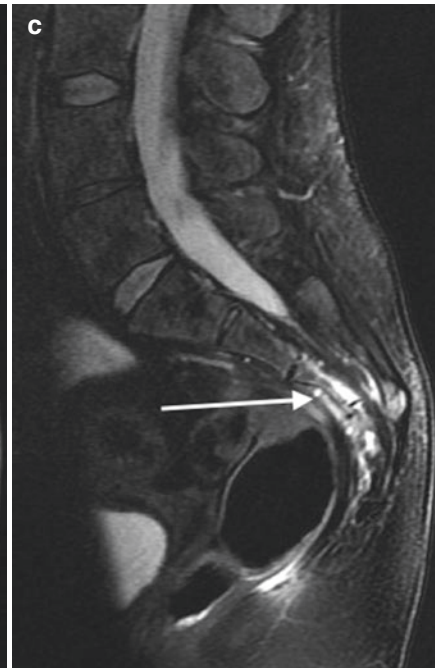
A 47-year-old female with gait disturbance. Posterior frontal projection (a) from bone scan shows focal spotty radionuclide uptake within the lower sacrum (arrow). T1-weighted sagittal image (b) shows focal hypointensity at S3 and S4 (arrow) with corresponding hyperintensity (arrow) on the T2-weighted sagittal image
